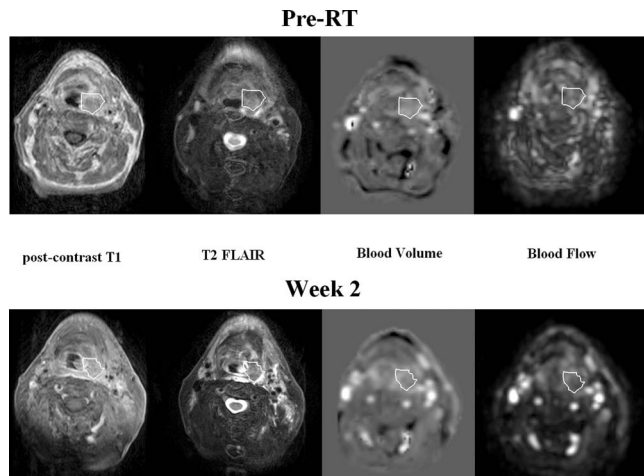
An example of postcontrast T1-weighted MRI (left), T2 FLAIR (second left), BV (second right), and BF (right) slices of a patient pre-RT (top row) and at week 2 (bottom row). White contour indicates the GTV.
